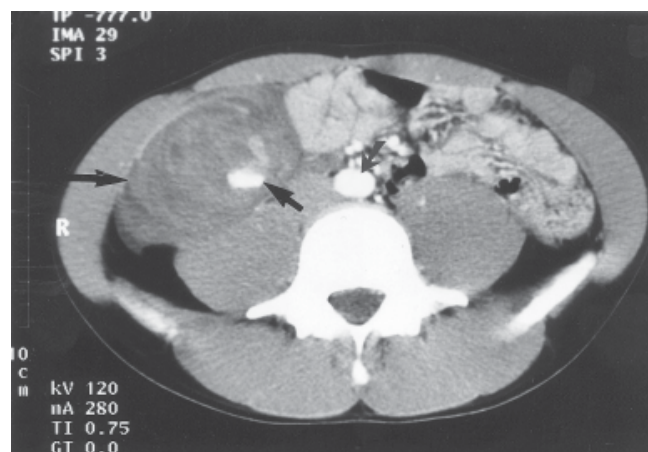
Abdominal CT scan showing caecal wall haematoma. Note the arrow pointing to the brightly contrasting bleeding vessel, of the same intensity as the aorta (small arrow).
